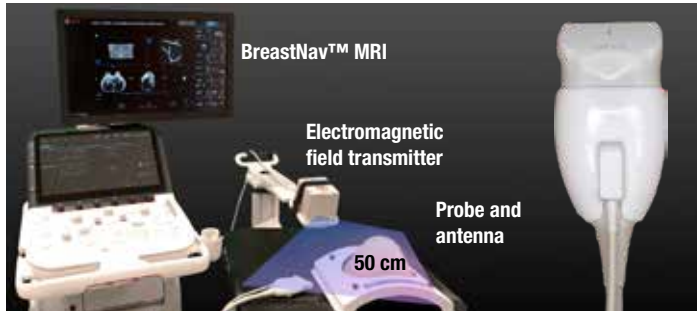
BreastNav™ MRI fusion imaging hardware components
